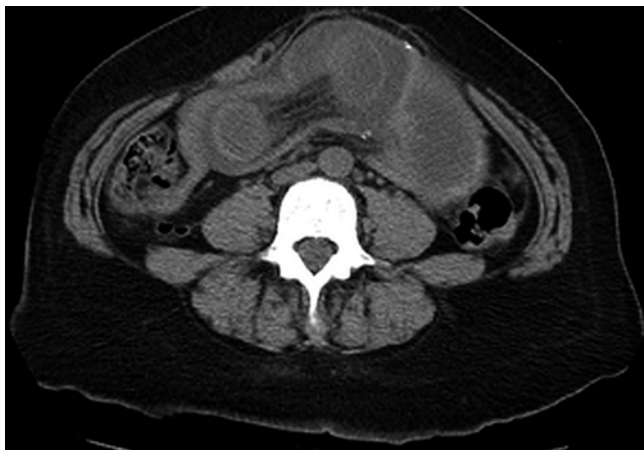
Typical “target sign” in abdominal CT characteristic of intussusception
